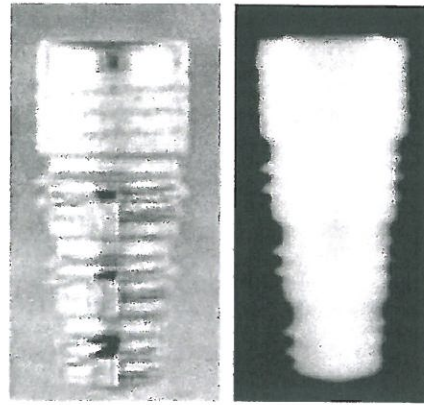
Friadent Frialit-2 Synchro Dental Implant (left original, right CT)
